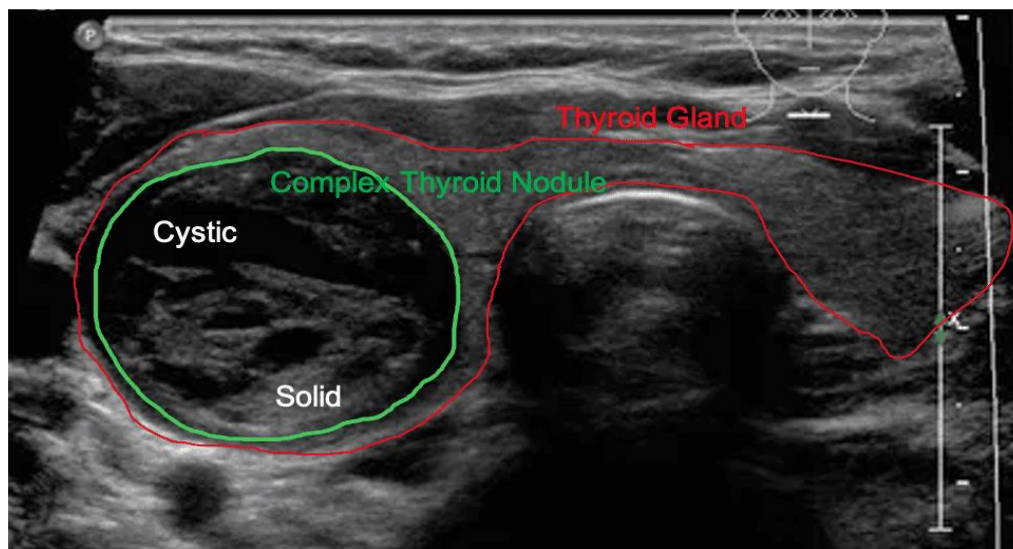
Ultrasonography of thyroid gland with cystic nodules (STARmed America, 2025)
